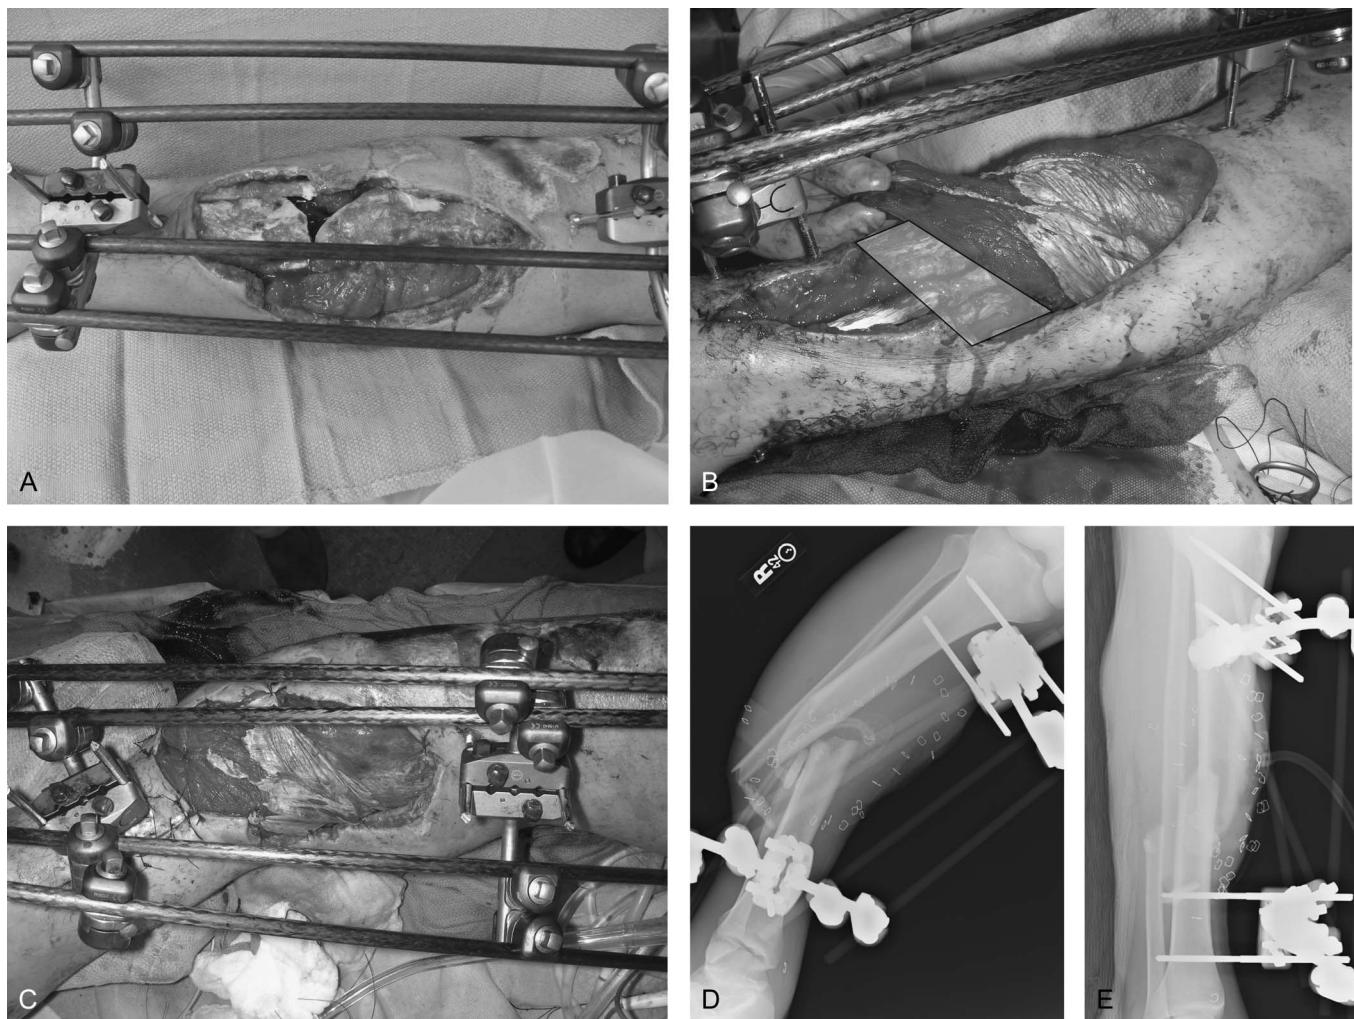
A, 22-year-old patient injured after his Humvee struck an improvised explosive device, sustaining a III-B open tibia fracture with large anteromedial soft tissue defect and bone loss involving the middle third of the leg. B, After maximal soleus rotational coverage, large area of distal wound remains open (shaded area) measuring approximately 25 cm². C, Shortening and angulation closes the gap, with the distal fasciotomy incision closed primarily. Varus alone was required to close the wound. D, E, AP and lateral radiographs at time of acute shortening with angulation.
